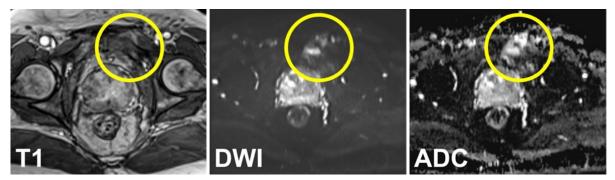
MRI showed an abnormality in the left superior pubic ramus.
